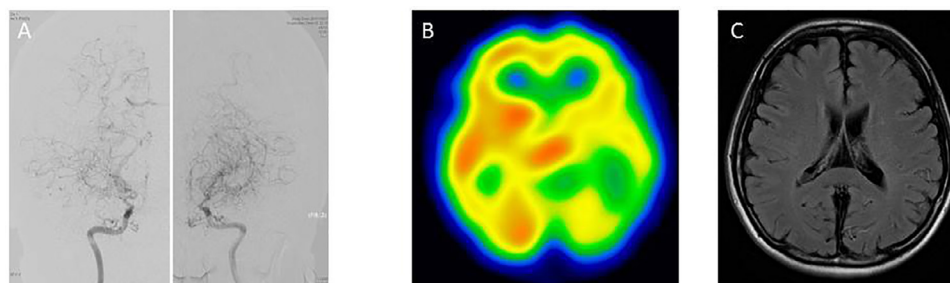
(A) Preoperative catheter angiography showing stenosis of the terminal portion of bilateral internal carotid arteries and abnormal vascular network at the base of the brain. (B) N-isopropyl-p-[¹²³I] iodoamphetamine single photon emission computed tomography (¹²³I-IMP SPECT) showing decreased cerebral blood flow in the territory of the left middle cerebral artery (MCA). (C) Fluid-attenuated inversion recovery (FLAIR) magnetic resonance (MR) imaging showing ivy signs in the left hemisphere.
